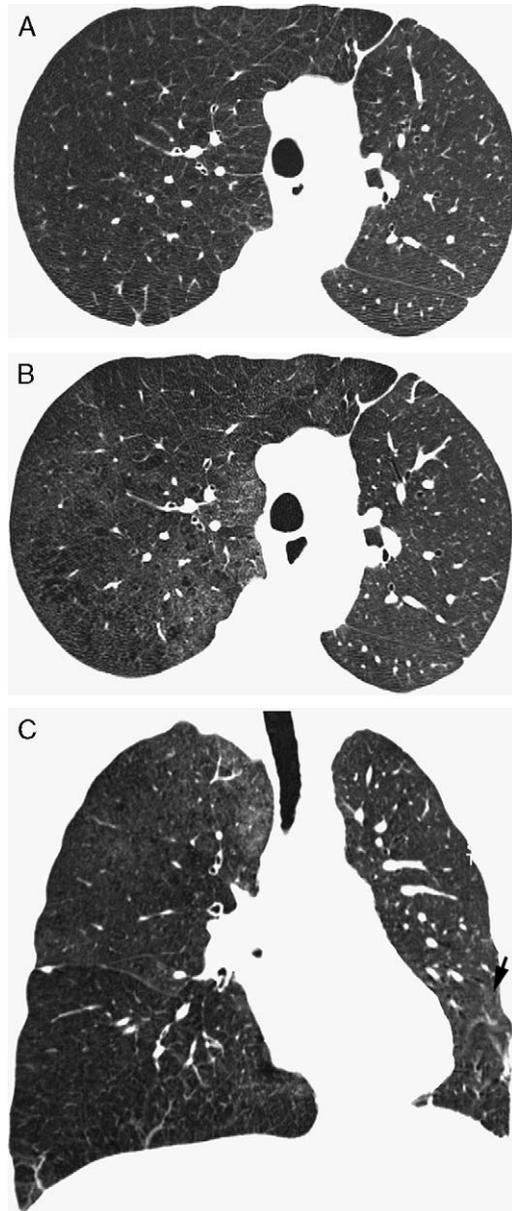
A 46-year-old man with panacinar emphysema and recurrent talcosis due to intravenous injection of oral Ritalin (methylphenidate). A, High-resolution CT image obtained on a multidetector CT scanner demonstrates panacinar emphysema in the native right lung. No abnormalities are noted in the transplanted left lung. B, High-resolution CT image obtained at the same level as A 3 years later shows development of diffuse nodularity and ground-glass opacities within the native right lung. C, Coronal image better demonstrates the marked hyperinflation of the emphysematous right lung. Also note diffuse micronodules in the right lung and ground-glass opacities in the right upper lobe. The left lung is relatively normal apart from a small focus of ground-glass opacity in the lingula. The patient had panacinar emphysema due to talcosis proven at the time of left lung transplant. Clinical history confirmed that the patient was continuing his habit of intravenous injection of oral Ritalin (methylphenidate) after lung transplantation.
